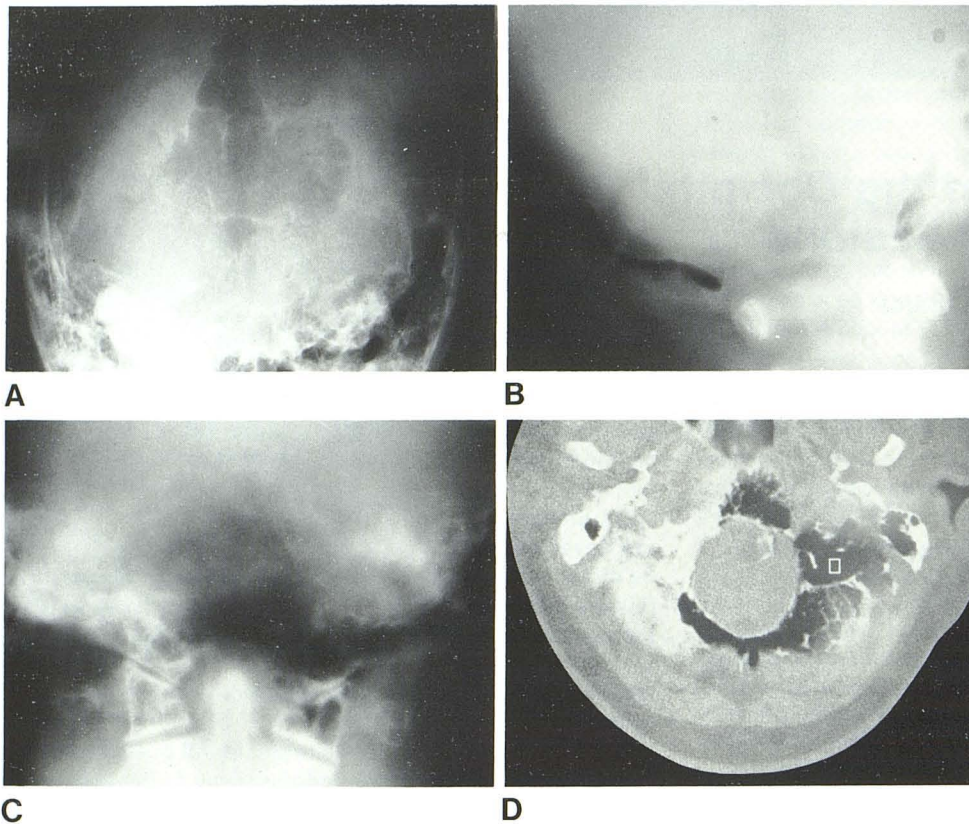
A, Towne view of skull shows 6 cm midline occipital radiolucency bordered by fine radiopaque rim and divided by several septa. Radiolucency borders foramen magnum and extends toward mastoids. Air density is difficult to appreciate on this view. B, Lateral polytomogram shows occipital air confined between inner and outer tables of skull and similar pneumatization of clivus. C, Frontal polytomogram shows pneumatization of occipital condyles and of lateral masses of atlas without occipitalization of atlas. D, Axial CT of base of skull shows continuation of pneumatization around foramen magnum. Mean density of -232 Hounsfield units lies clearly below range of fat, such as might be seen in dermoids.
